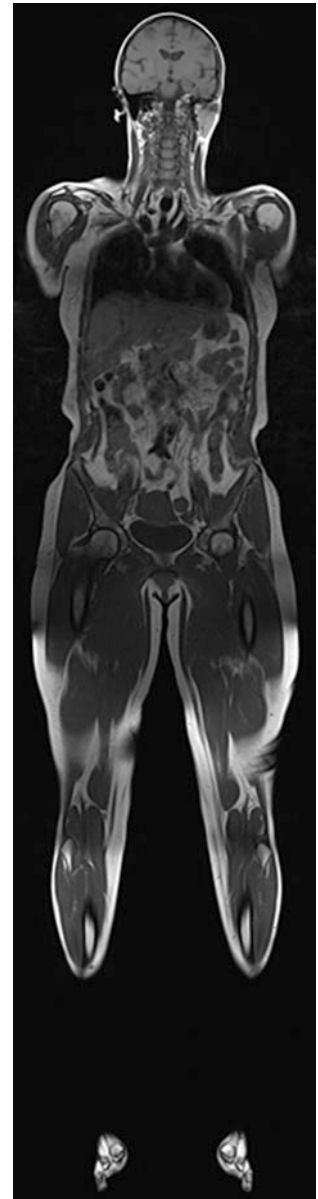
Whole-body MRI. To obtain whole body MRI images, the entire body is covered in coils (image courtesy of Prof. Dr. M. A. Weber, Heidelberg)
